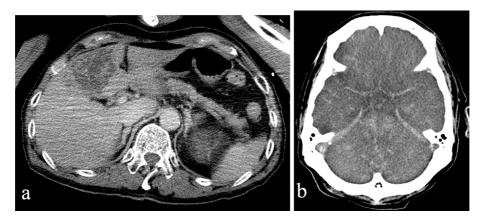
a) Contrast-enhanced abdominal computed tomography (CT) on admission. A single mass-like solidity region with heterogeneous contrast is visible in the right hepatic lobe. b) Non-contrast-enhanced brain CT on the sixth day of admission. Pseudo-subarachnoid hemorrhaging signs due to severe cerebral edema can be observed.
